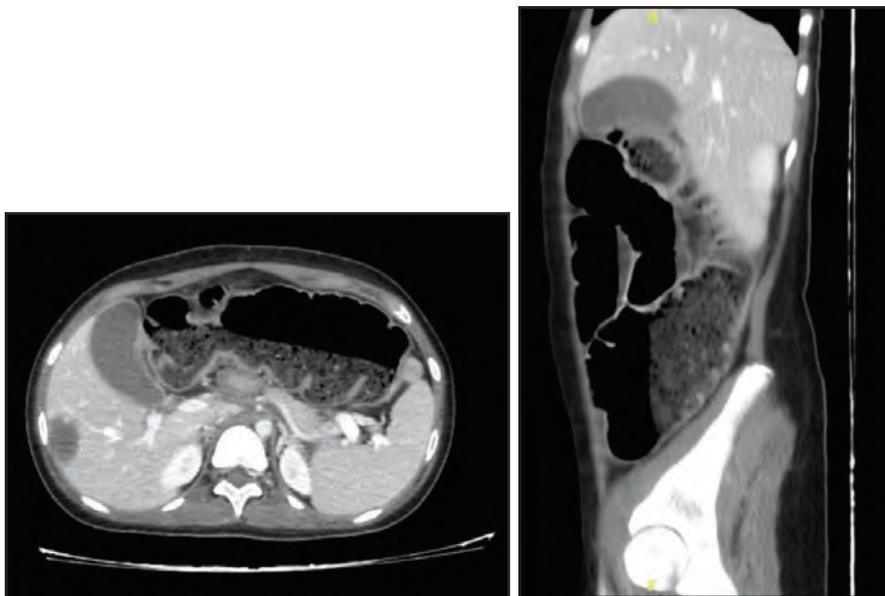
Pre surgery Abdominal CT Scan with contrast showing the tumor has metastasized to the liver
